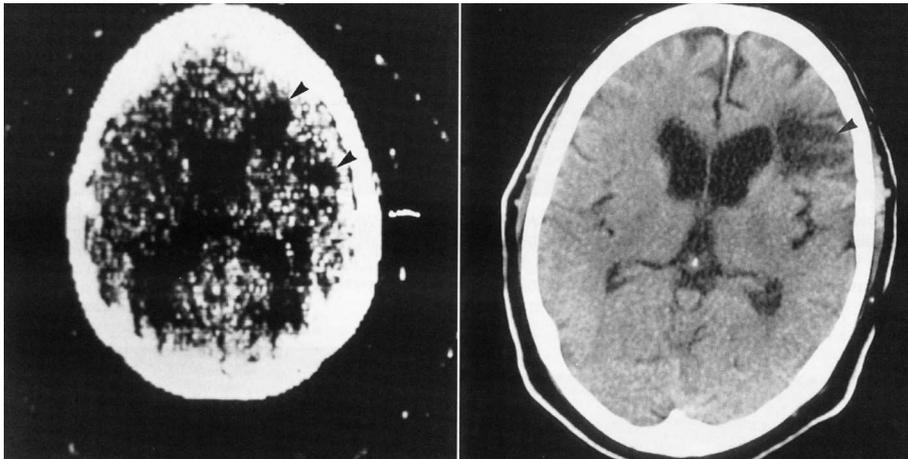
left*: CT image from first-generation scanner (cf. Fig. 1.1 left), about 1976. *right*: CT image from later-generation scanner (cf. Fig. 1.1 right). In both images, focal areas of cortical and subcortical loss can be discerned (arrows), probably representing ischemic disease. [from ORRISON *et al.*, 1995]
